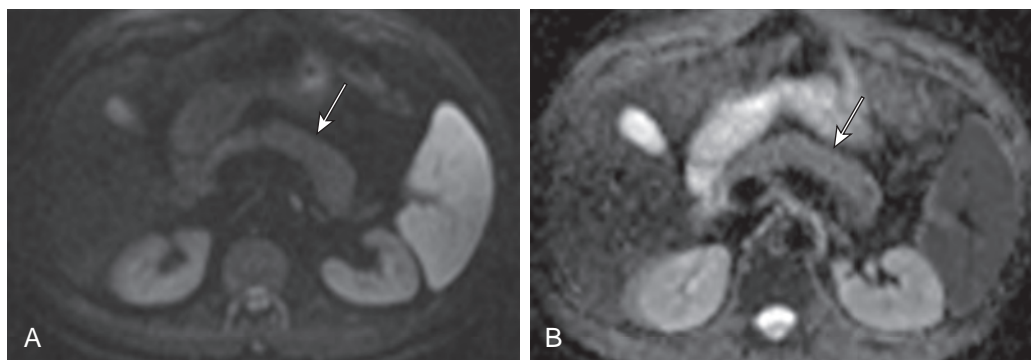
Normal diffusion-weighted MR image of the pancreas. A. Axial diffusion weighting ($b = 500 \text{ s/mm}^2$) shows normal homogeneous bright signal of the pancreas (arrow). B. Axial apparent diffusion coefficient map shows the normal appearance of the pancreas (arrow). The pancreas is homogeneous, and there are no areas of restricted diffusion.
